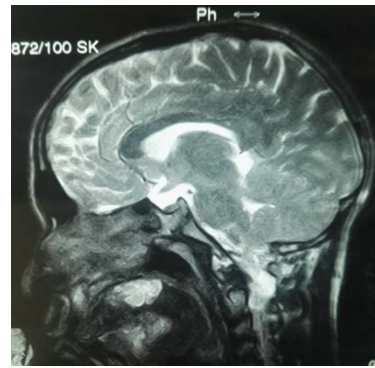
Preoperative-contrast T1-weighted magnetic resonance images of the patient
